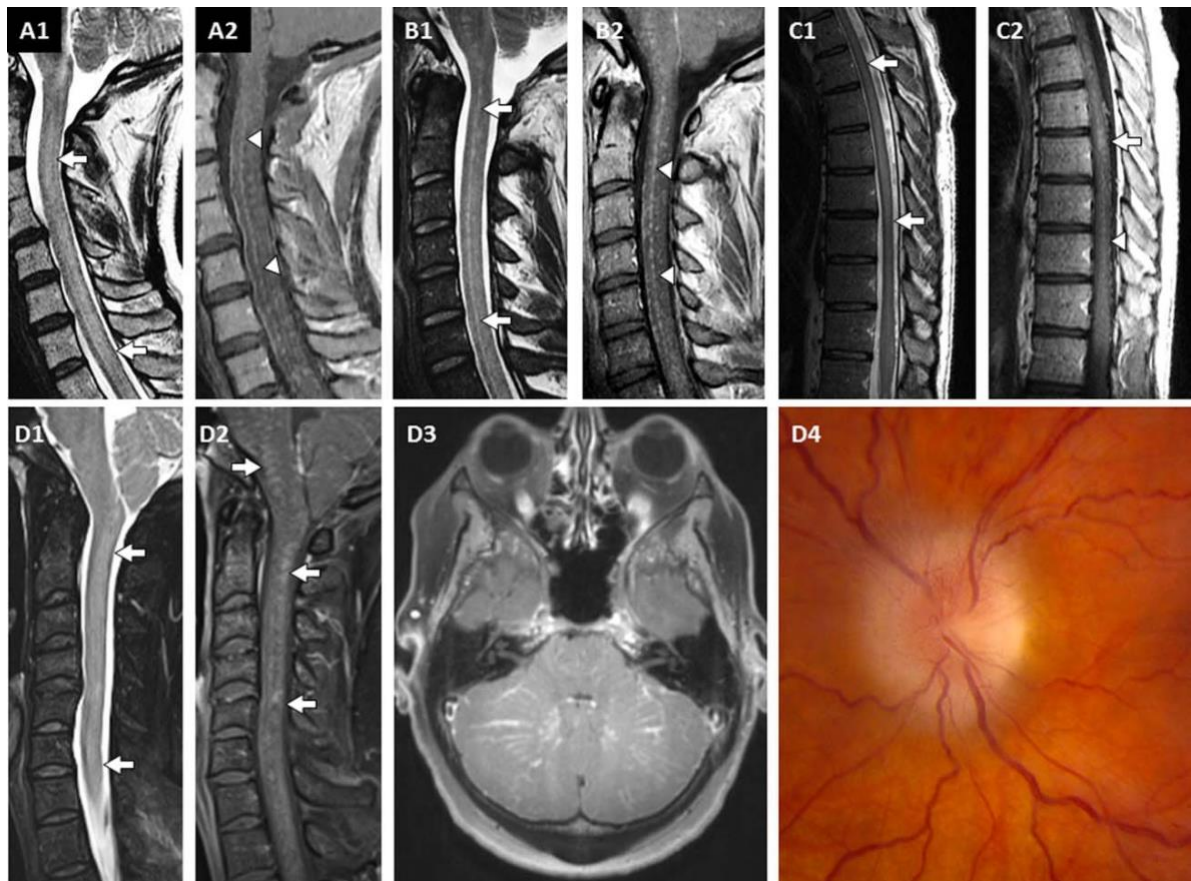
MRI scans of patients with GFAP meningo-encephalomyelitis and their characteristic findings in the spinal cord (A1-D2), cerebellum (D3), and a funduscopy showing a disk edema (D4) responsible for blurred vision. Copyright: E. P. Flanagan *et al.*, “Glial fibrillary acidic protein immunoglobulin G as biomarker of autoimmune astrocytopathy: Analysis of 102 patients,” *Ann. Neurol.*, vol. 81, no. 2, pp. 298–309, Feb. 2017.
